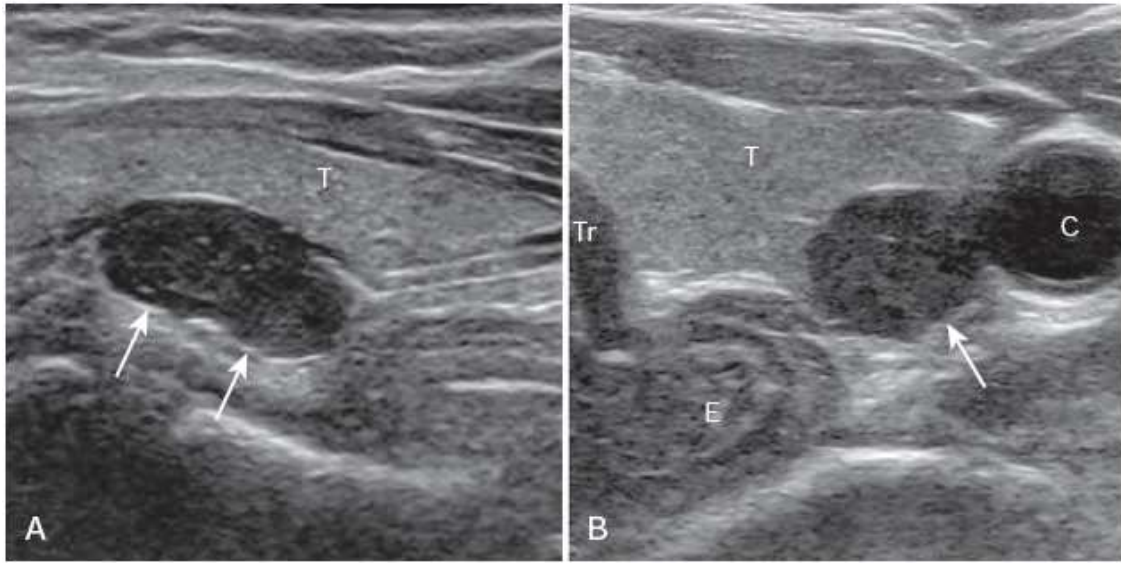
Superior parathyroid adenoma A, Longitudinal, and B, transverse, sonograms show an adenoma (*arrows*) adjacent to the posterior aspect of the midportion of the left lobe of the thyroid (*T*); *C*, common carotid artery; *E*, esophagus; *J*, internal jugular vein; *Tr*, trachea.
